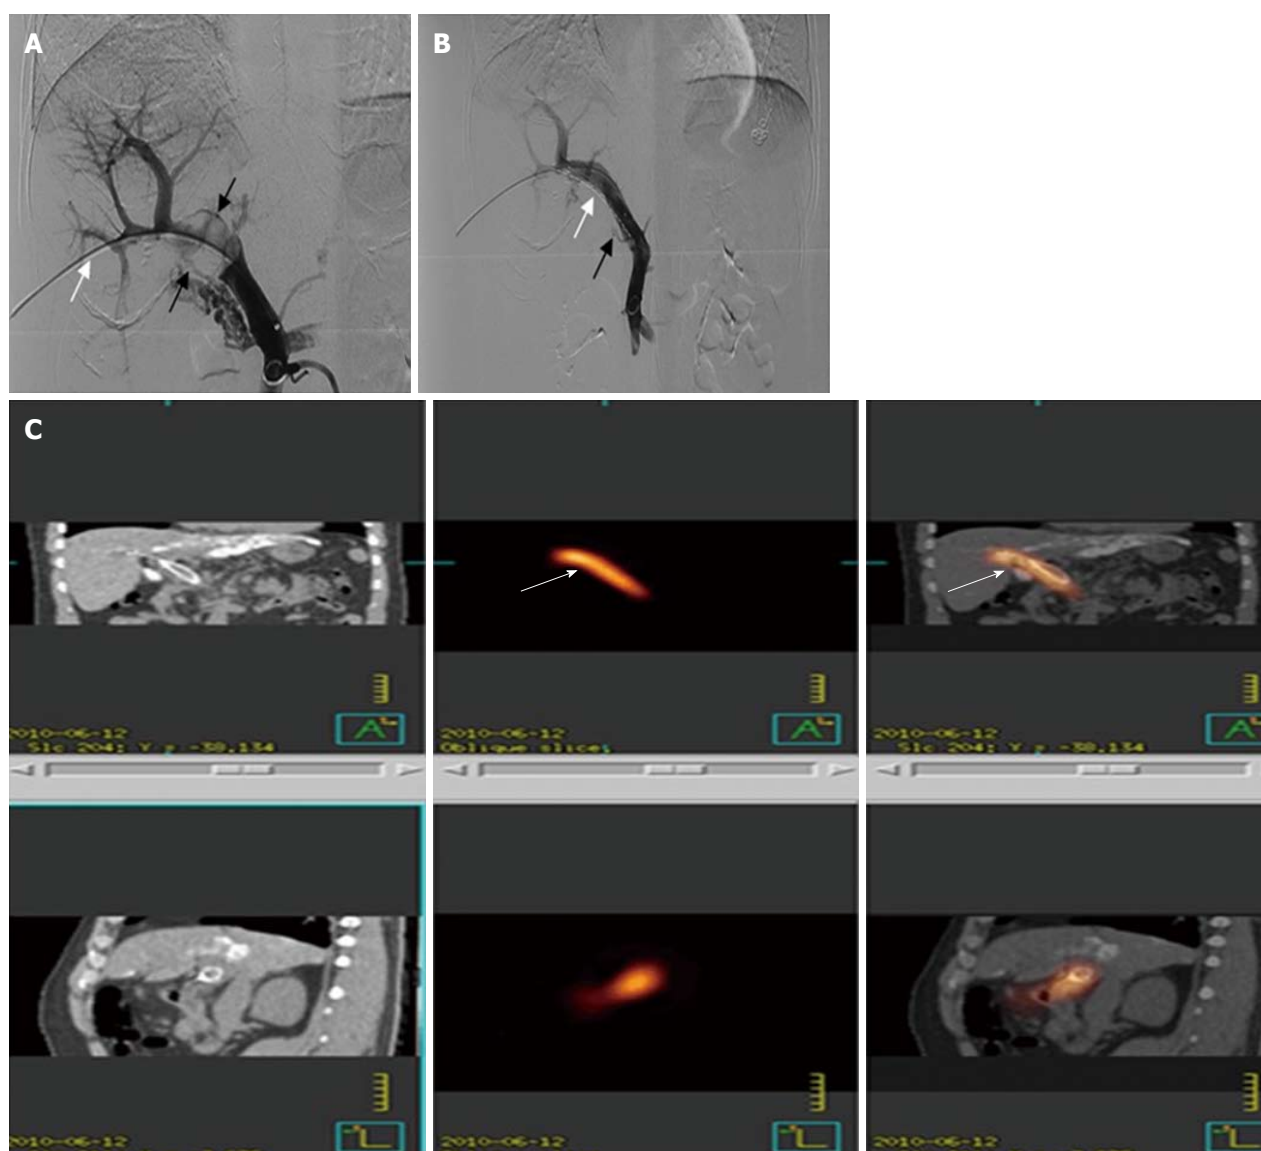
Images of iodine-125 seed strand and stent placement. A: After the patent second-order branch of the left portal vein was catheterized, a 5-F calibrated pigtail catheter (white arrow) was placed in the splenic vein. Tumor thrombus (black arrows) in the proximal MPV and sagittal segment of right portal vein was shown clearly on portography, but the right portal vein did not develop. B: A 14-mm x 80-mm self-expandable stent (black arrow) and ^{125}I seed strand (white arrow) with 20 seeds loaded were placed precisely in the obstructed MPV. C: Images of SPECT/CT scan 1 d after therapy. MPV: Main portal vein.
